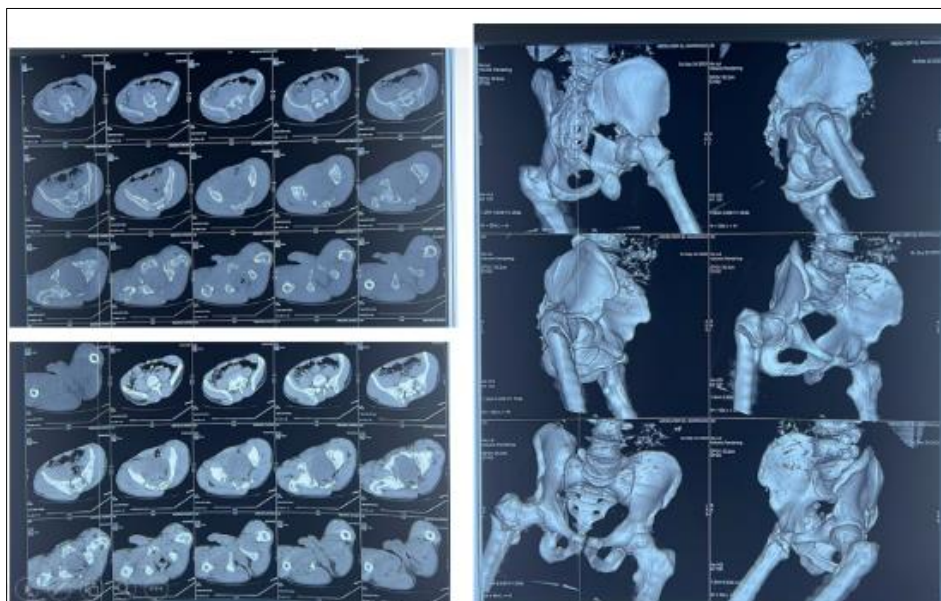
CT scan with 3D reconstruction: juxtacetabular transverse fracture of the acetabulum with central dislocation of the femoral head
